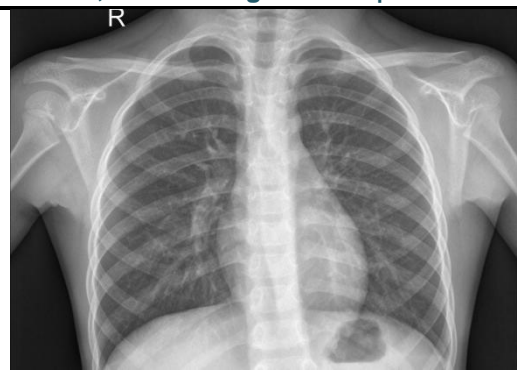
Brows picture of chest x-ray to detect covid19
